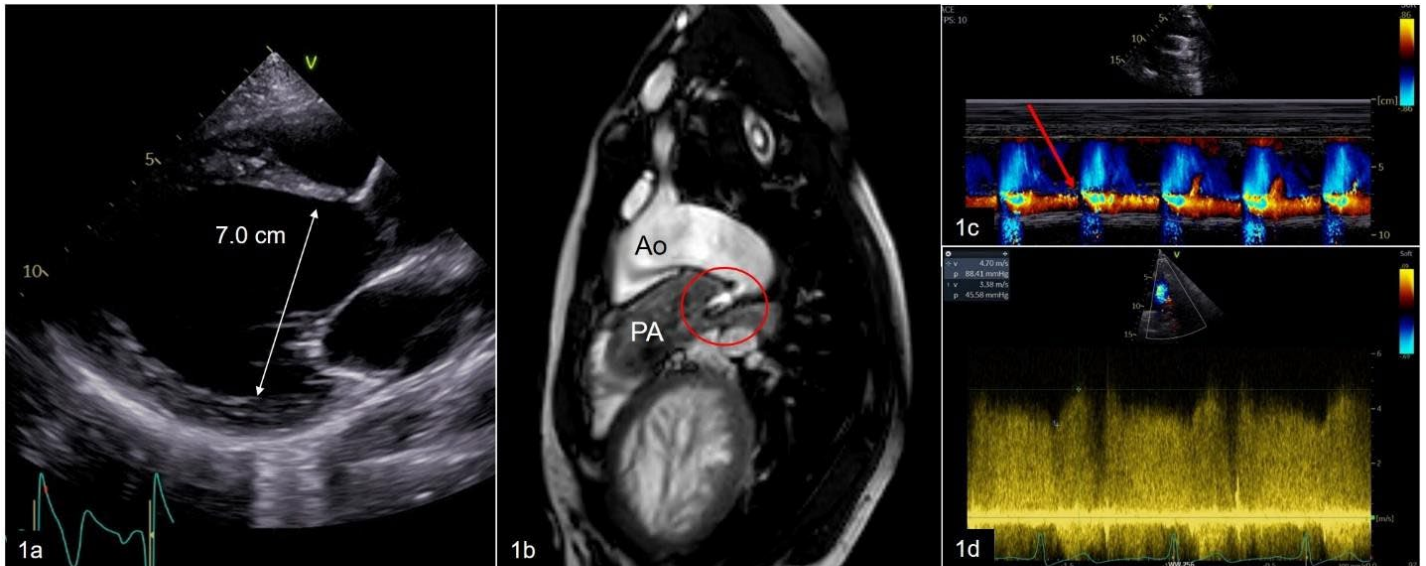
TTE showing significant LV dilation (white arrow = LVEDD); 1b: Cardiac MRI with a large PDA (red circle; Ao = aortic arch, PA = pulmonary artery); 1c: Color M-mode across the PDA with continuous left-to-right shunt (red arrow); 1d: CW-Doppler with high peak velocity and high pressure gradient between aorta and pulmonary artery.
